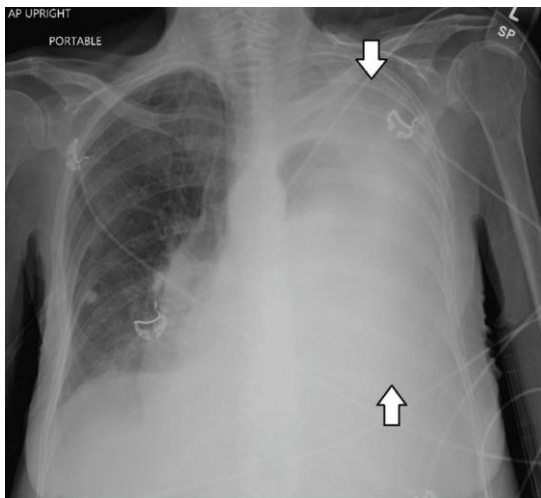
Portable upright AP chest radiograph of a patient with massive left pleural effusion due to hepatic hydrothorax before thoracentesis.
